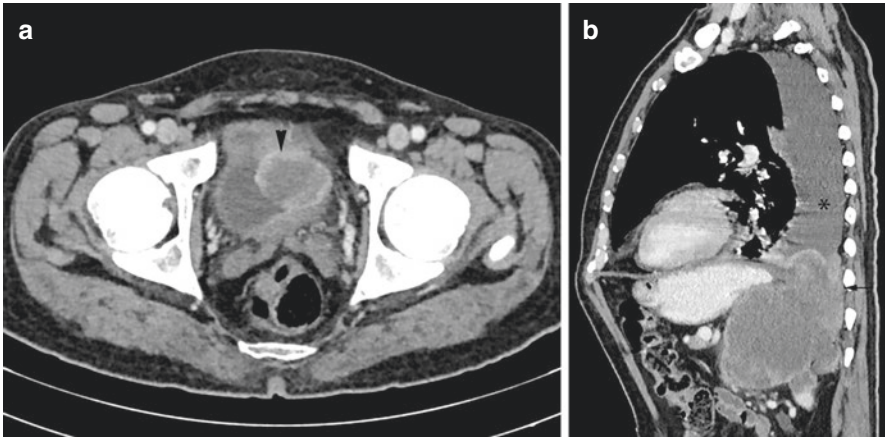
Sub diaphragmatic deposit and pleural effusion in patient with carcinoma UB. (a) axial contrast enhanced CT, and (b) sagittal contrast enhanced CT images show enhancing UB mass (*black arrowhead*), with sub diaphragmatic deposit invading diaphragm (*black arrow*), and pleural effusion (*black asterisk*)
